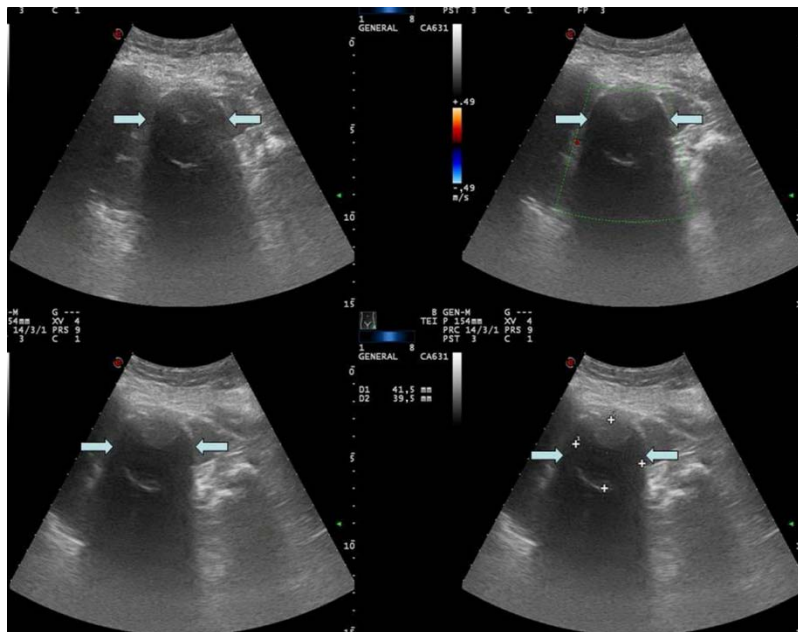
Abdominal ultrasound. Confirms the presence of an avascular hypoechoic splenic injury with peripheral calcification (arrows).
